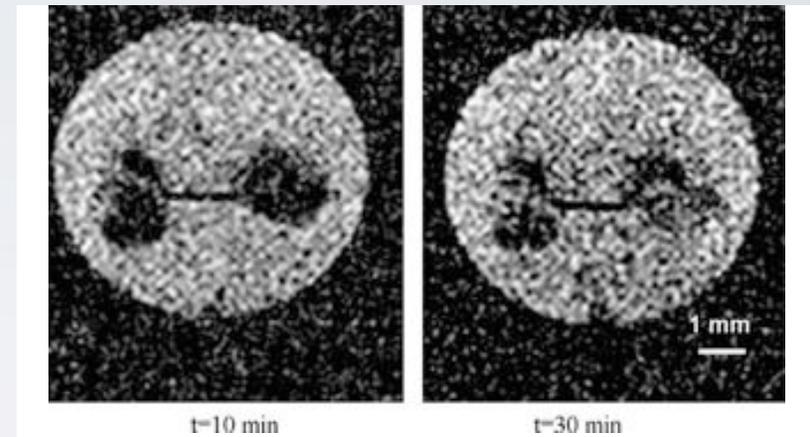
Two sample MR images, with water signal saturated, showing the increasing EG concentration in ovaries during perfusion.
